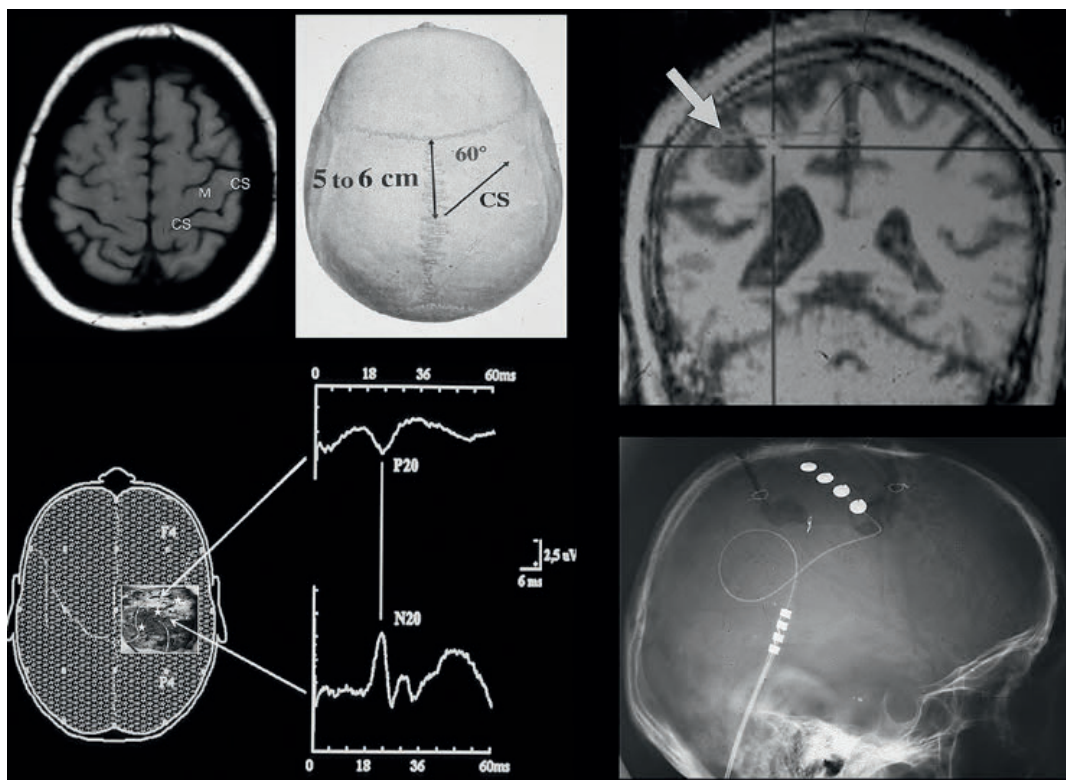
Motor cortex stimulation (MCS): technical principles. The target for stimulation is the precentral gyrus, that is, the primary motor area (M), as shown on MRI (magnetic resonance imaging) (*upper left*). The skin incision and bone flap are centered according to classical bony landmarks (*upper middle*) and individual anatomic particularities* from image-guided neuronavigation (*upper right*). Identification of the central sulcus (CS) is confirmed by somatosensory evoked potential (SSEP) recordings, in this patient using platinum ball electrodes (*lower left*). The CS is drawn on the surface of the dura at the very sites of the reversal of the N20 (postcentral) wave into the P20 (precentral) wave (*lower left*). Postop lateral X-ray shows the implanted electrode (a 4-contact Resume from Medtronic) (*lower right*).
